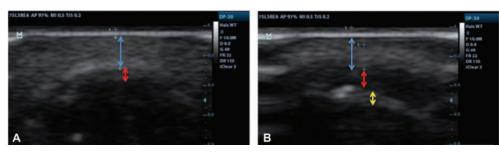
Preoperative sagittal ultrasonography (10 MHz, Phillips) of patient without nasal intervention and normal anatomy (A). Dermis and subcutaneous tissue (blue arrow) with 2.0 mm in diameter and thin superficial musculoaponeurotic system (SMAS) layer (red arrow) underneath with 0.8 mm. Twelve-month postoperative ultrasonography an additional fat layer (yellow arrow, 0.8 mm) can be distinguished^{Q8}.
